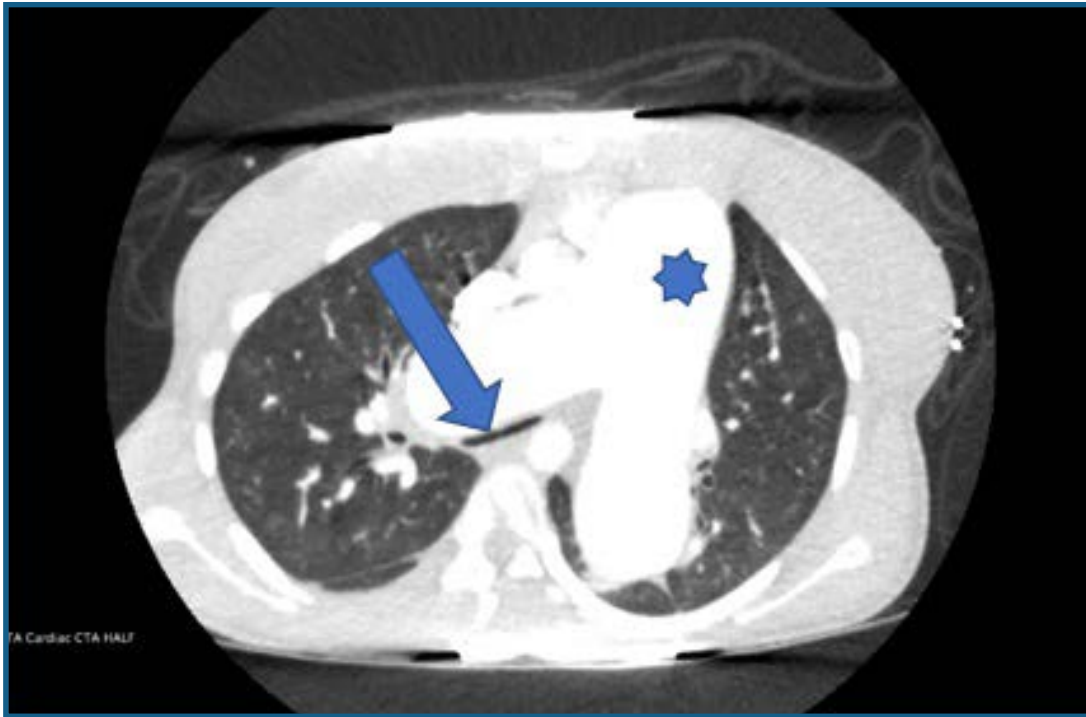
CT scan of the chest with IV contrast showing severely dilated pulmonary artery (star) with evidence of airway compression (arrow).
